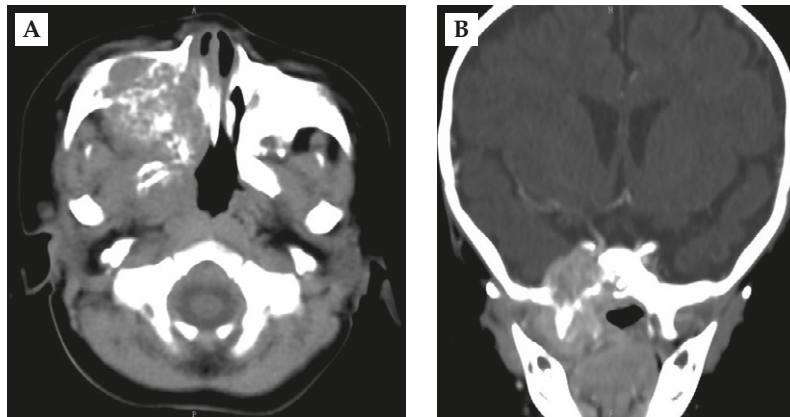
(A) Axial non-enhanced computed tomographic image showing a soft tissue mass (arrowhead) in the right maxillary sinus with adjacent bony destruction. (B) Coronal contrast-enhanced computed tomography shows the enhanced soft tissue mass (arrowhead) involving the right middle cranial fossa.
